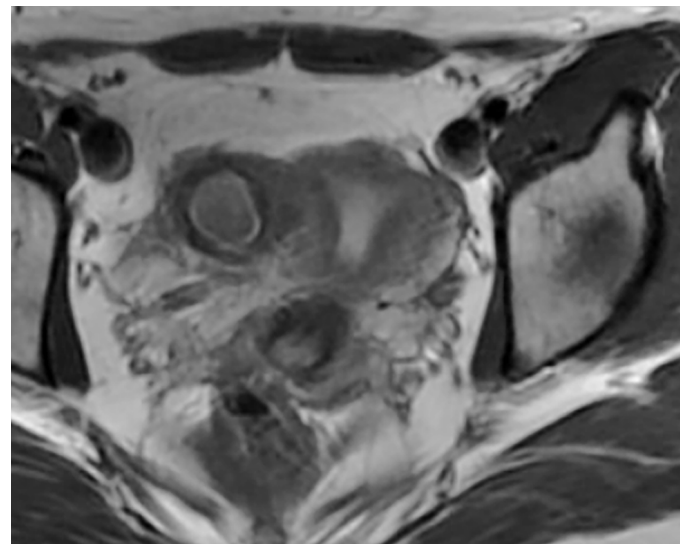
MRI of ACUM in the right lateral myometrium.
